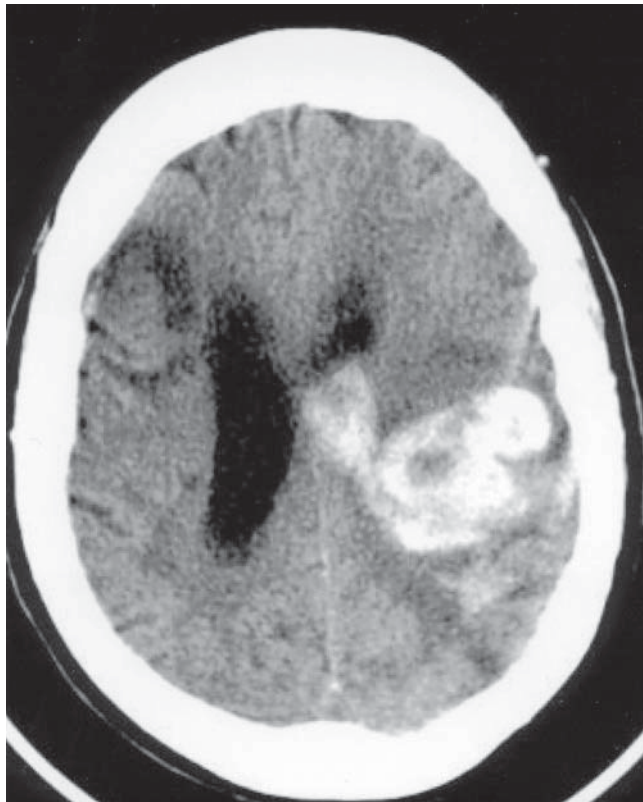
Shown is a computed tomography image of an acute hemorrhagic infarct, with intracerebral bleeding apparent.
